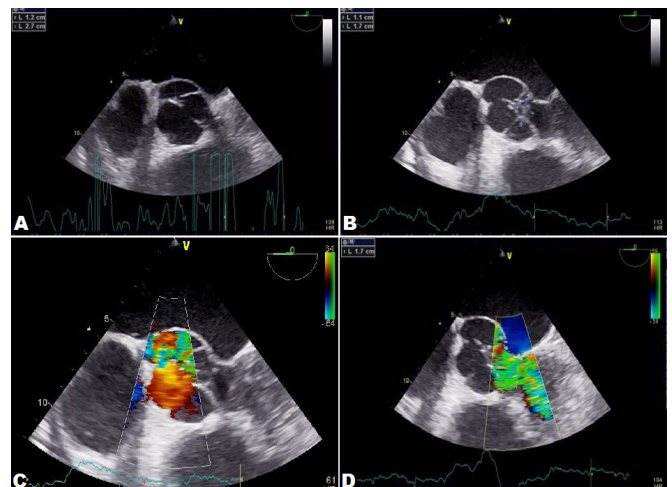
Transesophageal echocardiography. A) Pseudoaneurysm cavity formed due to abscess under the NCC and the commissure between NNC and LCC; B) Destroyed NCC and LCC with vegetation; C) Turbulent flow within the whole pseudoaneurysm cavity; D) Massive aortic regurgitation
